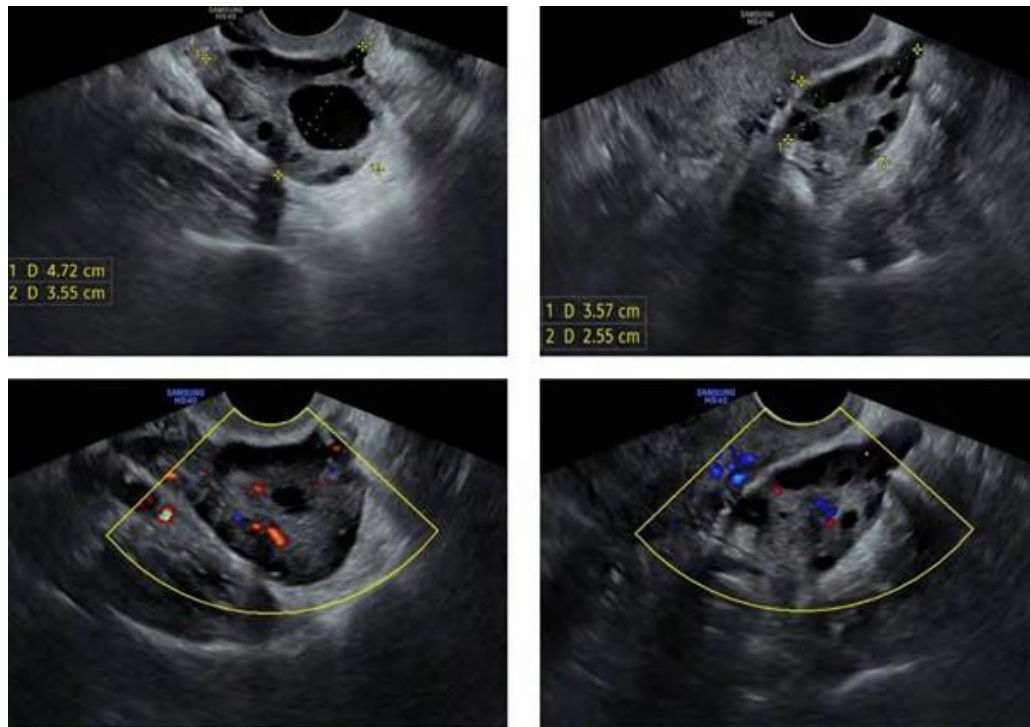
After the follow-up visit, ultrasound images of the patient's ovaries showed a normal ovary appearance. The right ovary measures 35.7X25.5 mm (right side of image), and the left ovary, 47.2X15.5 mm (left side), appears enlarged with a polycystic appearance. Doppler imaging showed normal blood flow in both ovaries.
